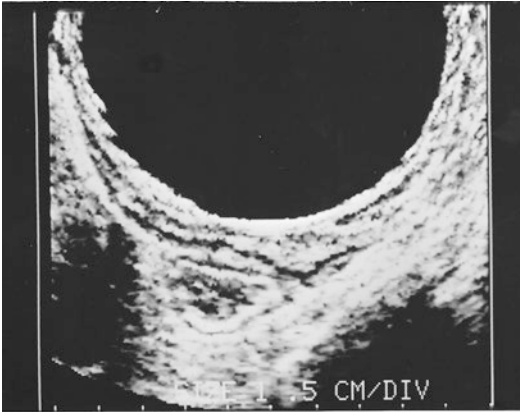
Ultrasound can distinguish masses in the rectal wall from extramural lesions, determine the relationship of tumors to the muscular layers of the rectum and the anal sphincters as well as differentiate between cystic and solid lesions
